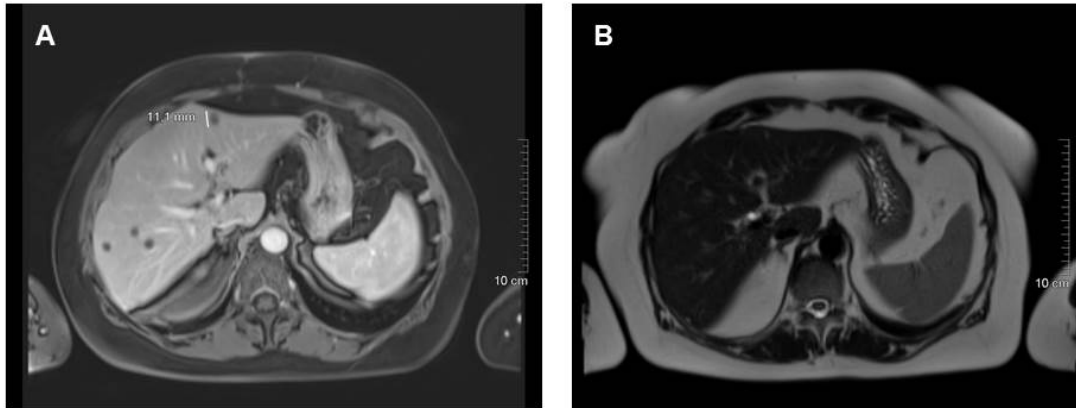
MRI scan (T1w, T2w). (A) Multiple, round, hypodense liver lesions about 1 cm in diameter. (B) Absence of cystic lesions in T2 weighted sequences
